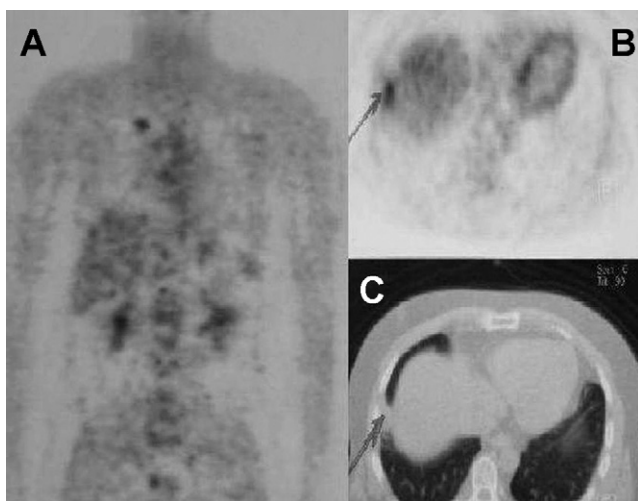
(A) Uptake suggestive of malignancy in the previous bullectomy site of patient 1. (B–C) PET and CT scans of the right lower lobe nodule of patient 3.
